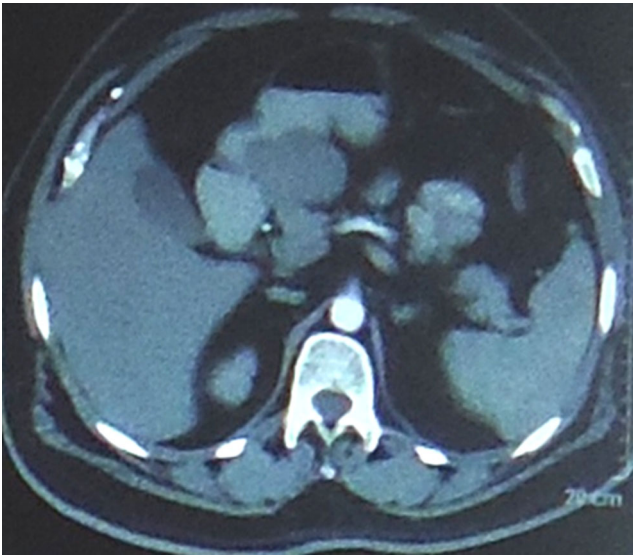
CT scan showing exophytic mass in pylorus
